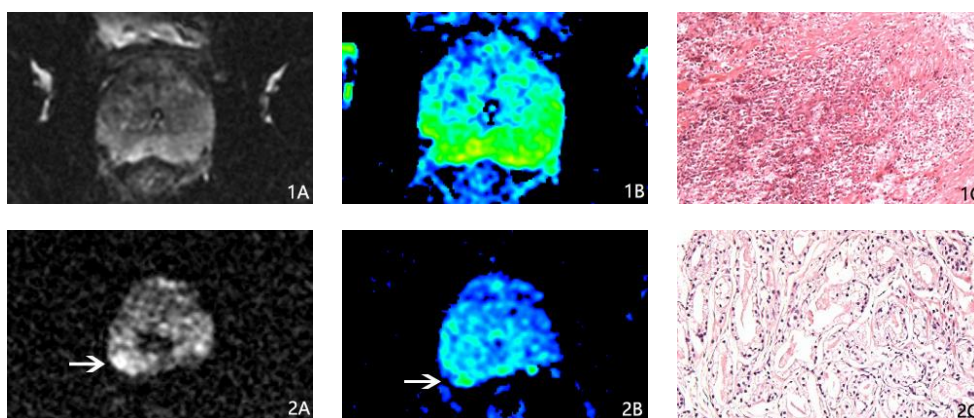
(1) A 64-year-old patient was confirmed to be prostatitis by pathology. (1A) DWI ($b=800s/mm^2$) and (1B) ADC_{slow} imaging (1C) pathologic imaging. (2) A 72-year-old patient was confirmed to be prostatic cancer by pathology. (1A) DWI imaging ($b=800s/mm^2$) and (1B) ADC_{slow} imaging show the tumor (white arrow) (1C) pathologic imagin
